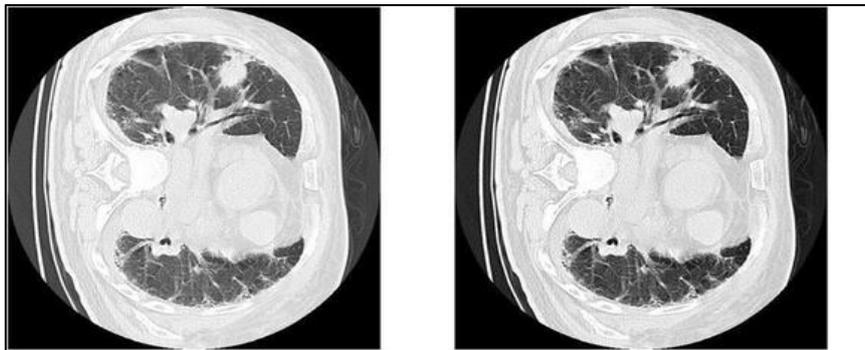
Original CT image (left) and its CLAHE based CT (right) [17]
